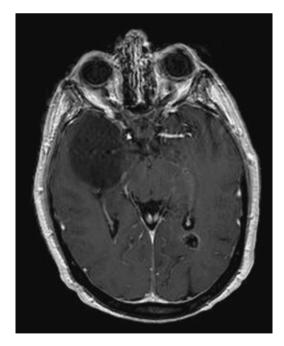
Axial section of magnetic resonance imaging of the brain showing a large tumor in the white matter of the right temporal lobe. The tumor did not cause vasogenic edema, but induced the partial collapse of the right temporal ventricle. A calcified meningioma in the occipital horn of the left lateral ventricle is also seen.
